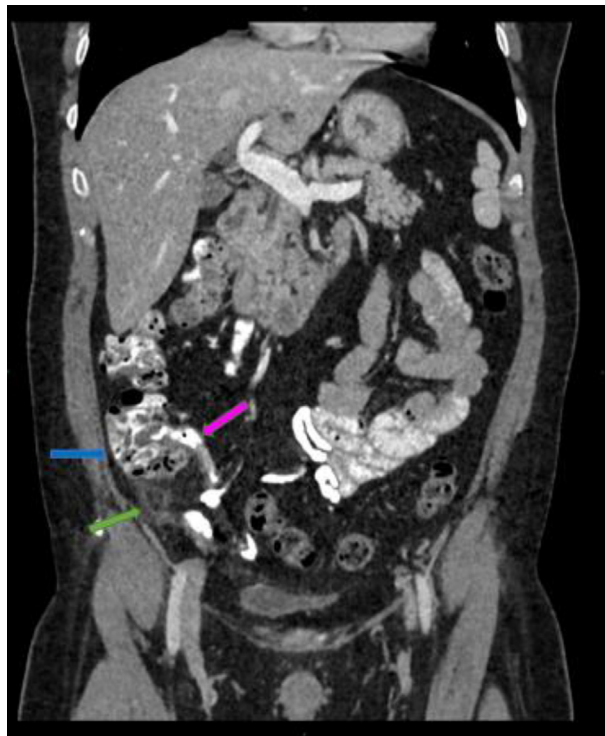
Contrast CT of the abdomen, coronal reformation, demonstrates normal caecum (blue arrow), normal ileocecal junction (pink arrow) and epiploic appendagitis (green arrow).
